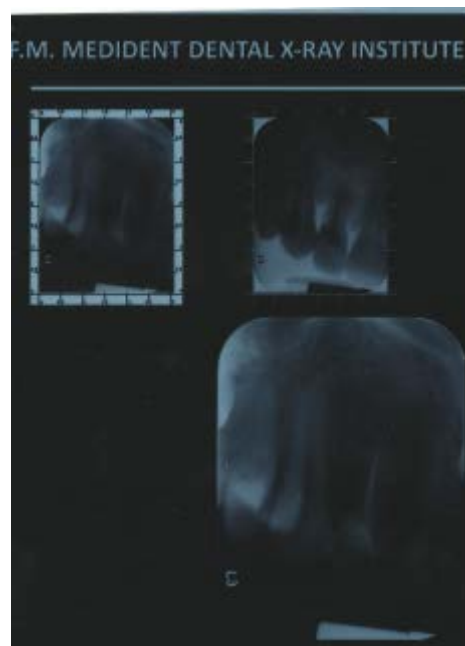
Initial intraoral radiograph showing large cervical resorption
